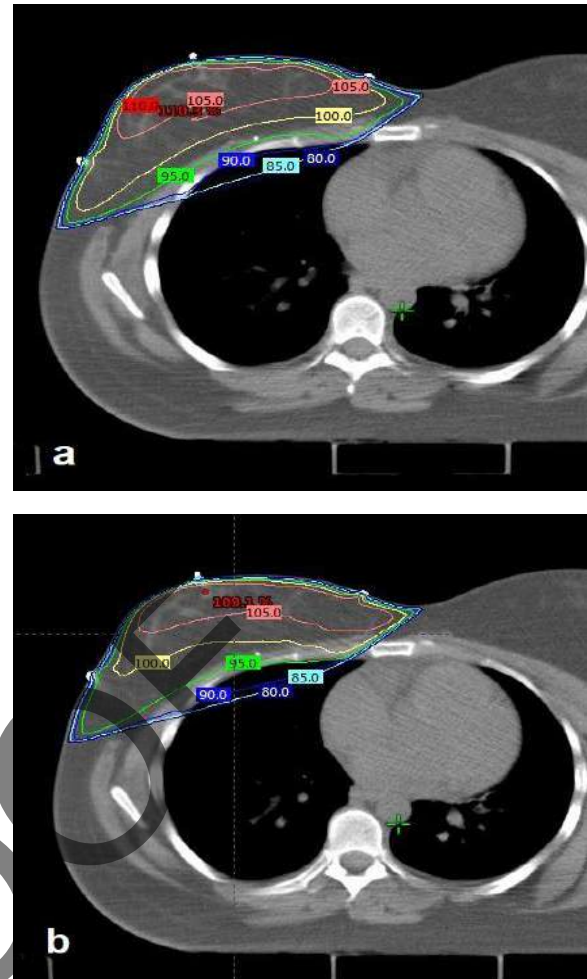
Central CT slice with dose distribution (calculated at the treatment planning system Eclipse) for the FIF technique (a) and the wedge technique (b)
